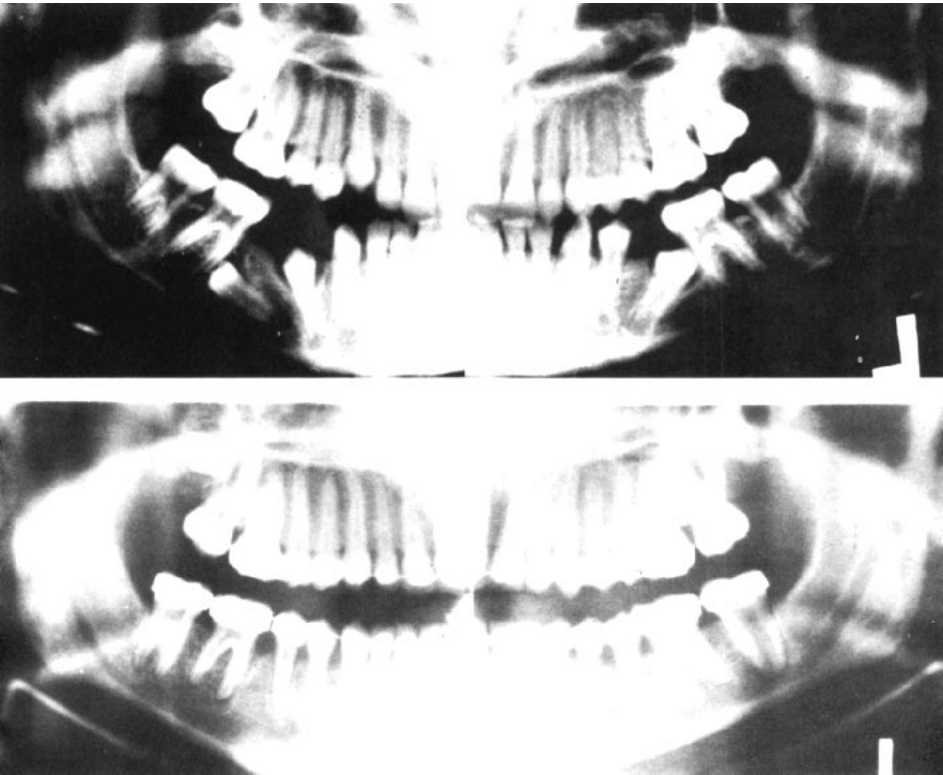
(a) Pretreatment radiograph showing distally inclined impacted second bicuspids. (b) Radiograph showing the same teeth in alignment. (Courtesy of Dr. K. Vig, Chapel Hill, North Carolina.)
